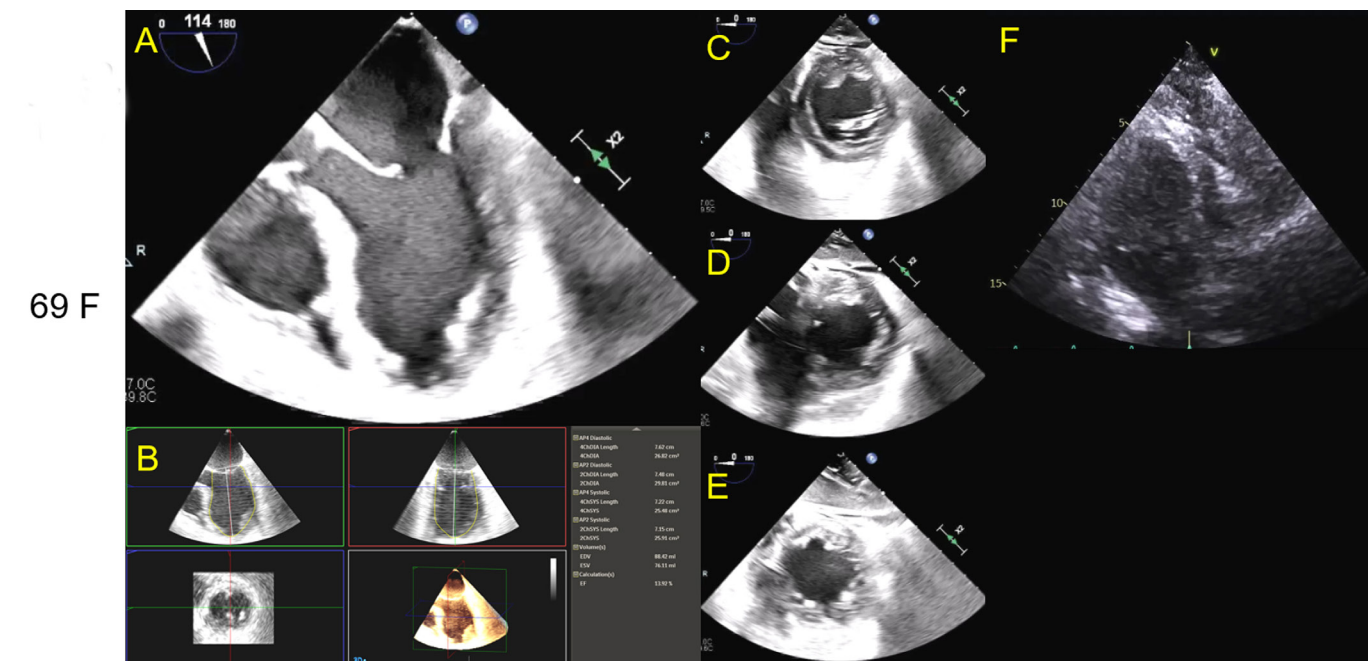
Intraoperative transesophageal echocardiography imaging of a mid-esophageal modified 5-chamber view (A), transgastric basal short-axis view, (C), transgastric mid-chamber short-axis view (D), and transgastric apical short-axis view (E). Left ventricular ejection fraction calculated at 14% via 3-D volumetrics (B). The images show basal contractility (C) with mid-chamber (D) and apical hypokinesis (E), consistent with Takotsubo/stress-induced cardiomyopathy. Post veno-venous extracorporeal membrane oxygenation on day 1 shows resolution of regional wall motion abnormalities in transthoracic apical 2-chamber view in Mayo Clinic format with the left ventricle on the left side of the screen (F).
